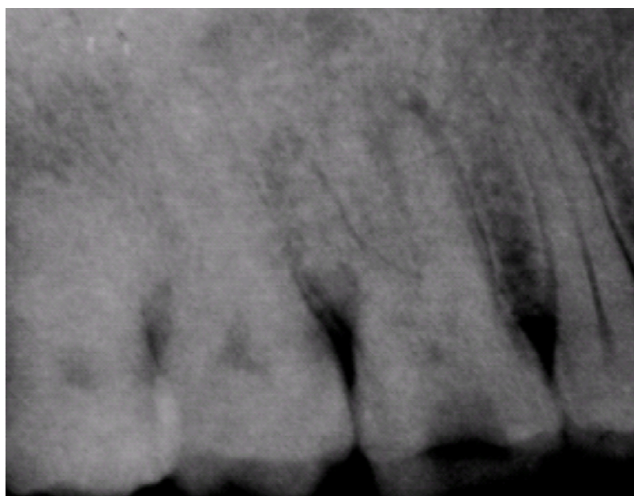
Shows a radiograph of tooth 16 which revealed periapical radiolucency with advanced caries.
